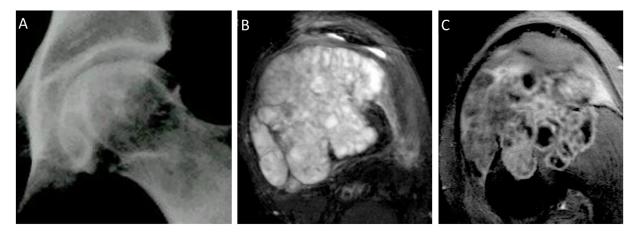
Plain radiograph (A) demonstrates a lytic lesion with partial sclerotic margins and chondral calcifications located in the central region of the left femoral head. MR shows a lobulated lesion with high signal on T2WI (B) and small foci of signal absence due to the calcifications. Intense peripheral enhancement (C) is shown on FS T1WI with contrast. Anatomopathology (not shown) revealed a clear cell chondrosarcoma.
